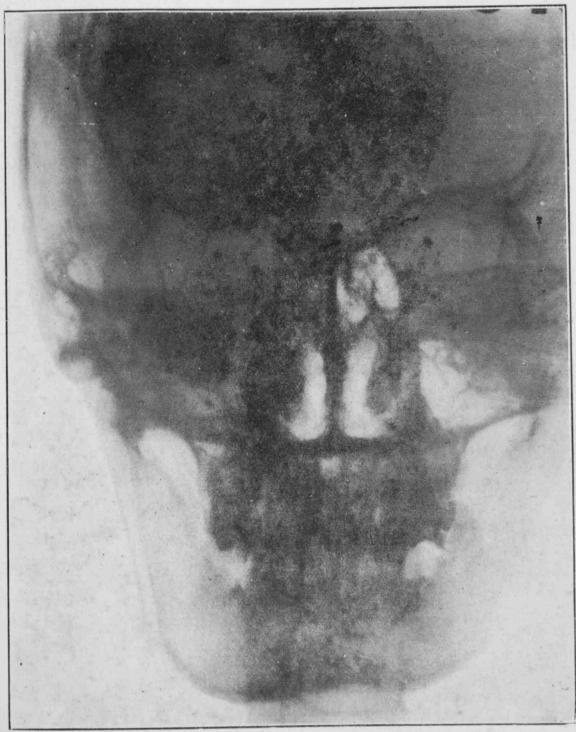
Condition of the sinuses according to the X-ray findings.
